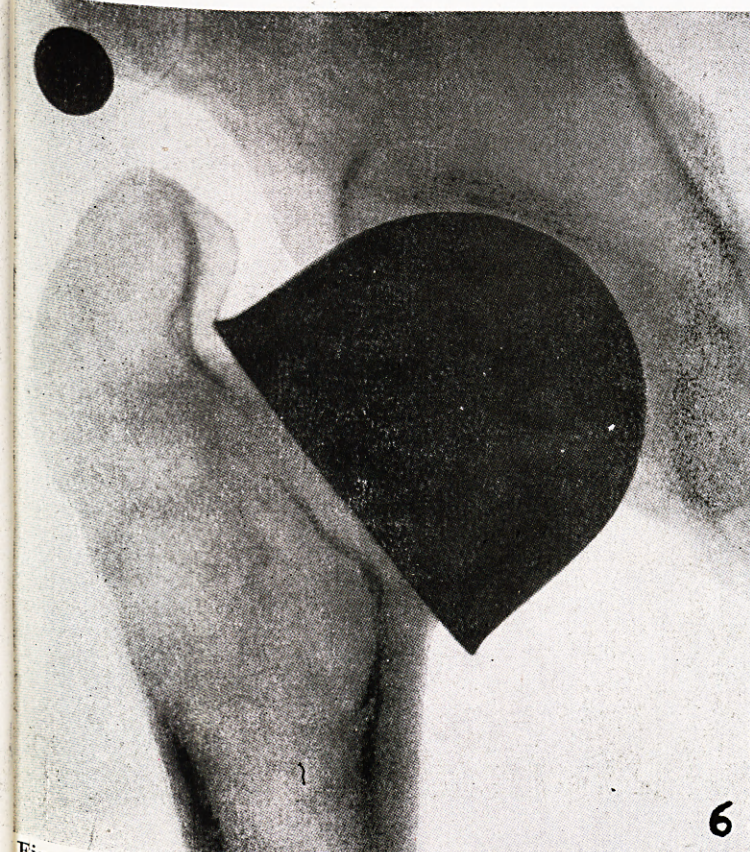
Is an x-ray photograph showing the results of the cup arthroplasty after 4 months. It is difficult to see the osteotomy line after fusion of the trochanter with the shaft.
